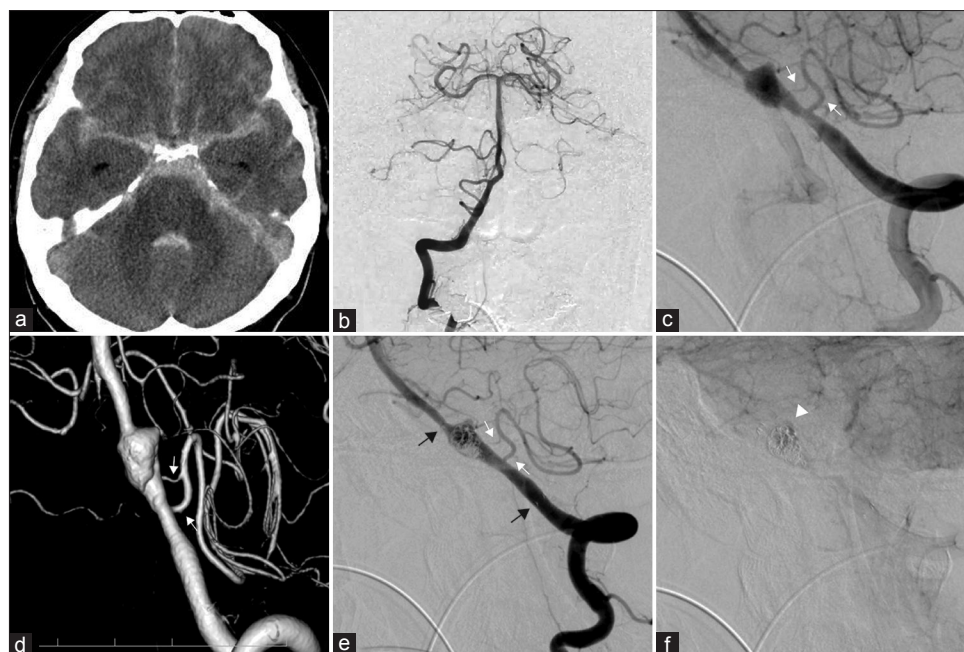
(a) A computed tomography scan on admission shows a massive subarachnoid hemorrhage. (b) Right vertebral angiography. (c) Left vertebral angiography demonstrates the stenosis and fusiform dilation of the left vertebral artery. (d) Three-dimensional digital subtraction angiography reveals double origin of the posterior inferior cerebellar artery: one from the dilatation itself, and the other from the stenosis proximal to the dilatation. (e) Coil embolization of the fusiform dilatation with stenting is performed (arrow; flared ends of the stent). Vertebral artery and posterior inferior cerebellar artery patency was preserved. (f) Postoperative digital subtraction angiography (venous phase) showed contrast medium stagnated in the fusiform dilatation. White arrows (c-e) show double origin of posterior inferior cerebellar artery
